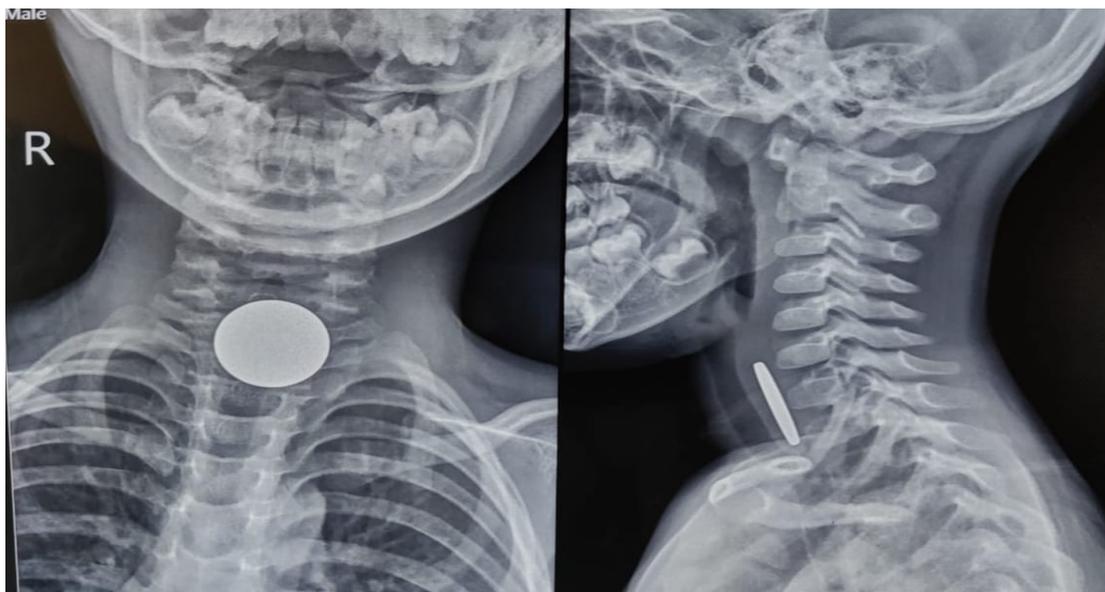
AP & Lateral radiograph of the neck revealing a swallowed coin at the level of the cricopharynx.
